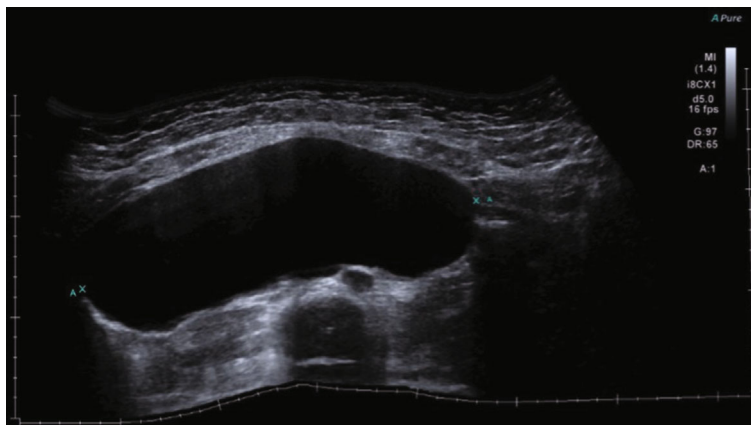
Transverse ultrasound view of the right adnexa, demonstrating the cyst. Note its homogenous echotexture.
